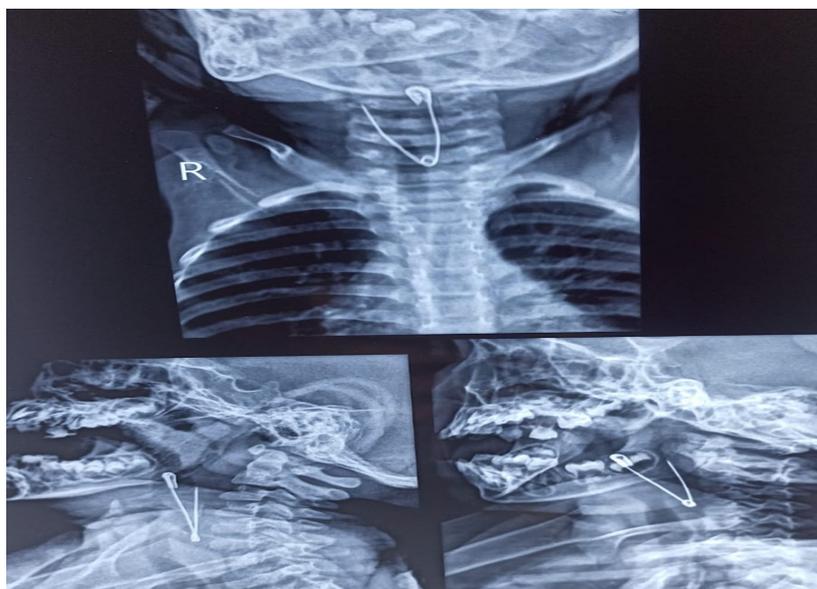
AP & Lateral radiograph of the neck revealing a safety pin
